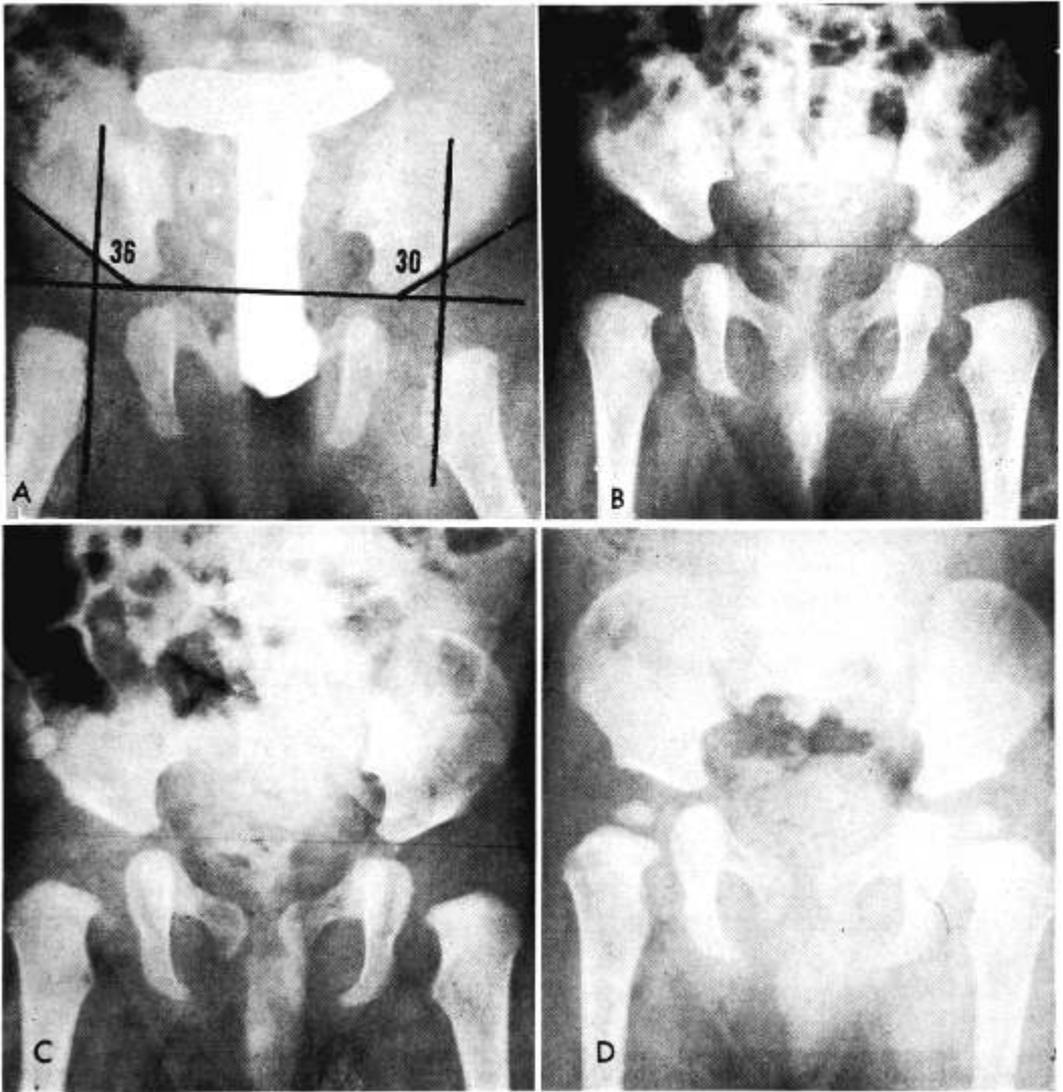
Case 3. On examination at 6 weeks of age, the right hip of this female infant could be easily displaced from the socket. The roentgenogram (A), taken 2 days after birth, shows lateral disposition of the "beak" and unilateral shortening of the "H" line on the affected side. The indices are within normal limits. The mother did not accept the proposed program of therapy. The film (B) was taken at 3 months of age and shows improvement, although the acetabular indices have not reduced at all. In (C) and in (D), taken at 6 months and at 1 year of age, respectively, steady progress toward normal development is demonstrated.
